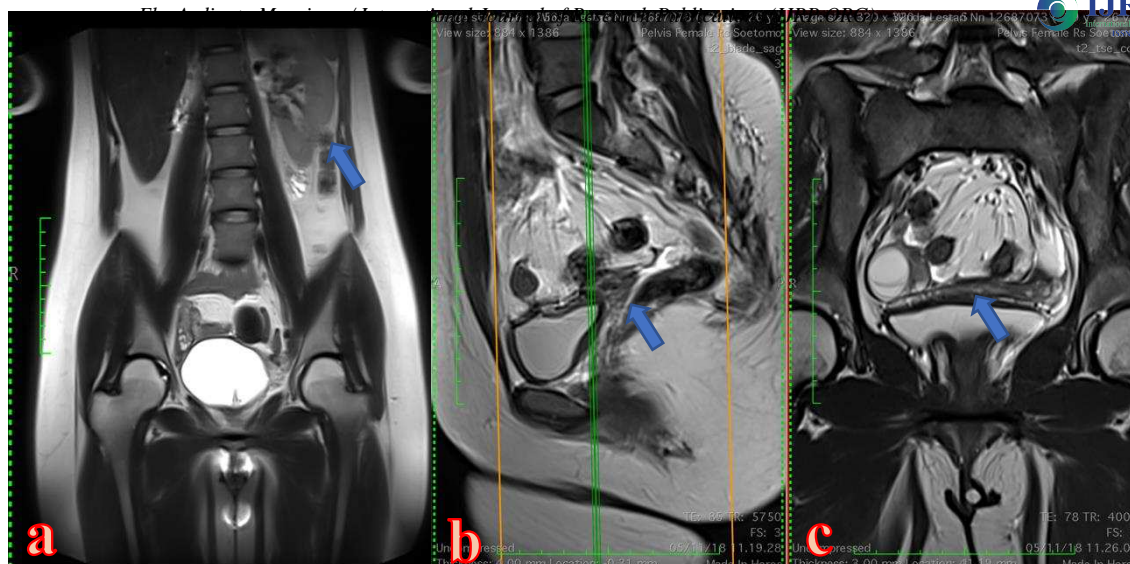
of a 28-year-old female patient with MRKH type 2. (a) Coronal MRI T2 shows normal left kidney in the fossa of the left kidney with no right kidney, (b) sagittal MRI T2 shows midline triangular soft tissue without cavities, (c) coronal MRI T2 shows isointense fibrous bands.
